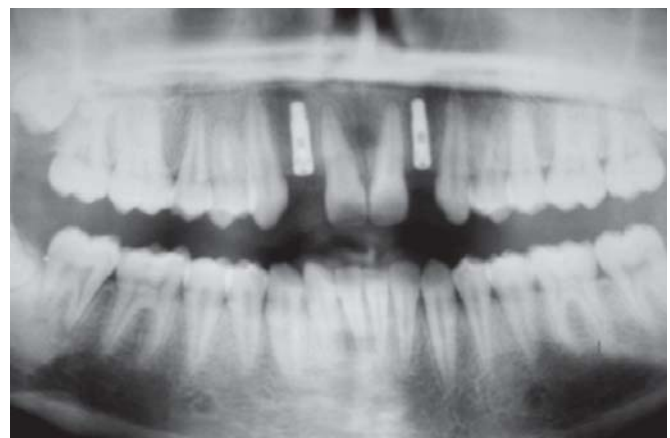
Panoramic radiograph of an adolescent patient. See the dental implant embedded in the region of congenitally missing bilateral maxillary lateral incisors
